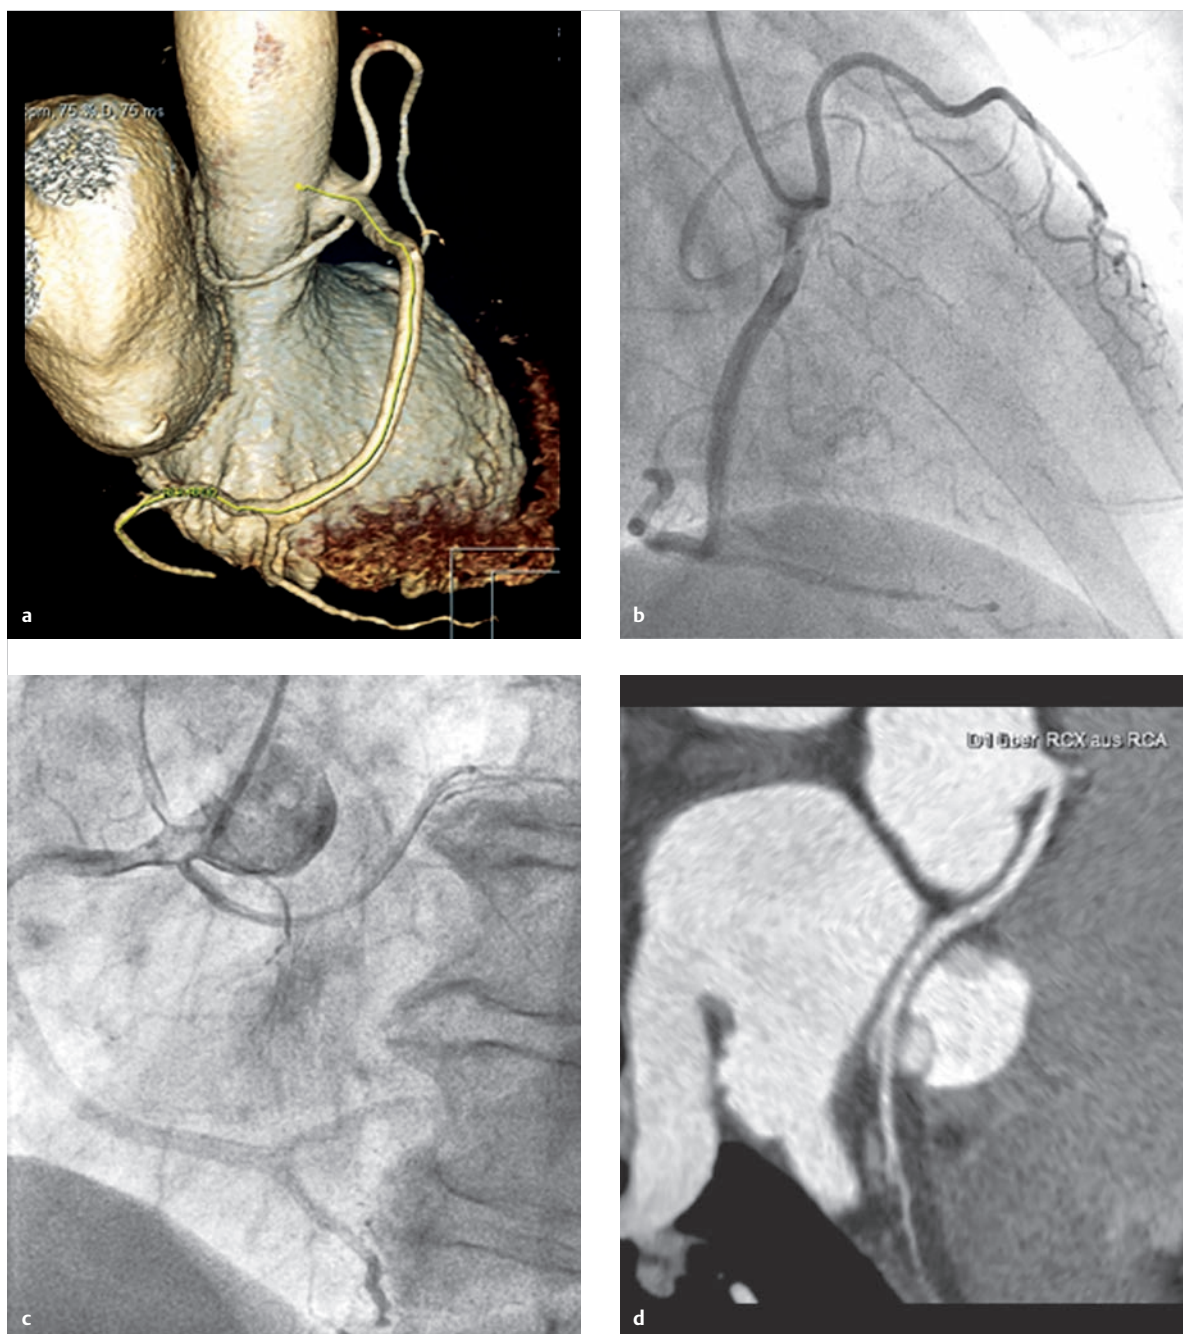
Common origin of the circumflex branch and anterior interventricular branch from the right coronary artery, which originates from the right coronary sinus. Sixty-nine-year-old female patient. The indication for invasive diagnostics was ruling out coronary heart disease before a planned mitral valve reconstruction. The subsequent CT was performed to better diagnose the position of the course of the coronaries during a planned, minimally invasive surgical intervention.
